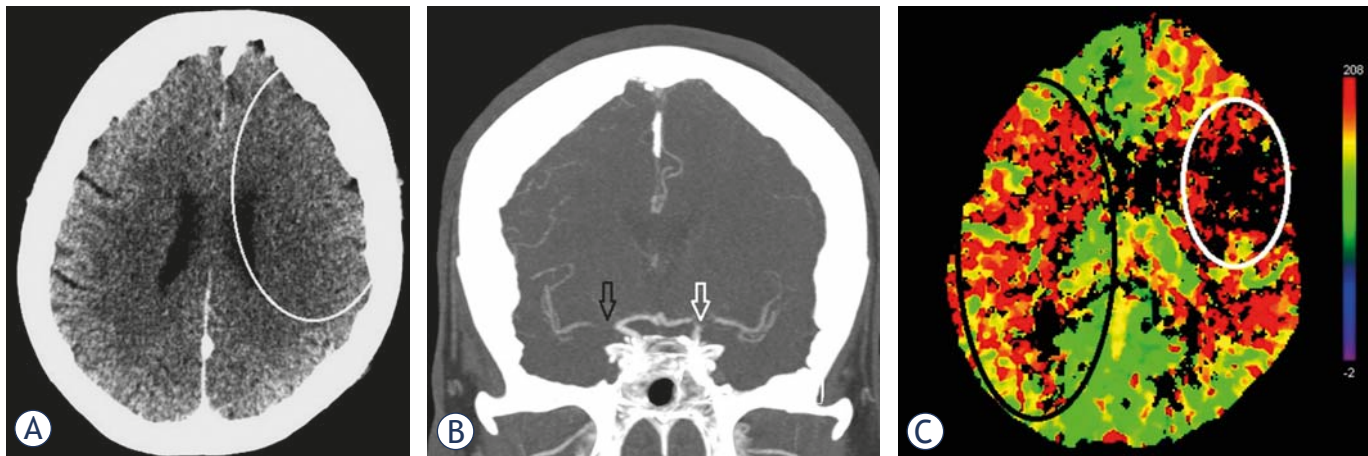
(A) Control images taken in the general hospital after clinical deterioration during intravenous thrombolysis and before the transfer to the tertiary institution. There were still no signs of ischaemic brain damage in the right cerebral hemisphere but there were subtle signs of stroke in the left middle cerebral artery (MCA) territory (white line delineates loss of cortical grey matter – white matter differentiation in the frontoparietal lobe with sulcal effacement). (B) Control images taken in the general hospital after clinical deterioration during intravenous thrombolysis and before the transfer. CT angiography (CTA) showed persistent right M1 occlusion (black arrow) but also left carotid “T” occlusion (white arrow). (C) Control images taken in the general hospital after clinical deterioration during intravenous thrombolysis and before the transfer. CT perfusion imaging (CTP) showed a penumbra in the right MCA territory (black circle) and irreversible brain damage in the left MCA territory (white circle).
